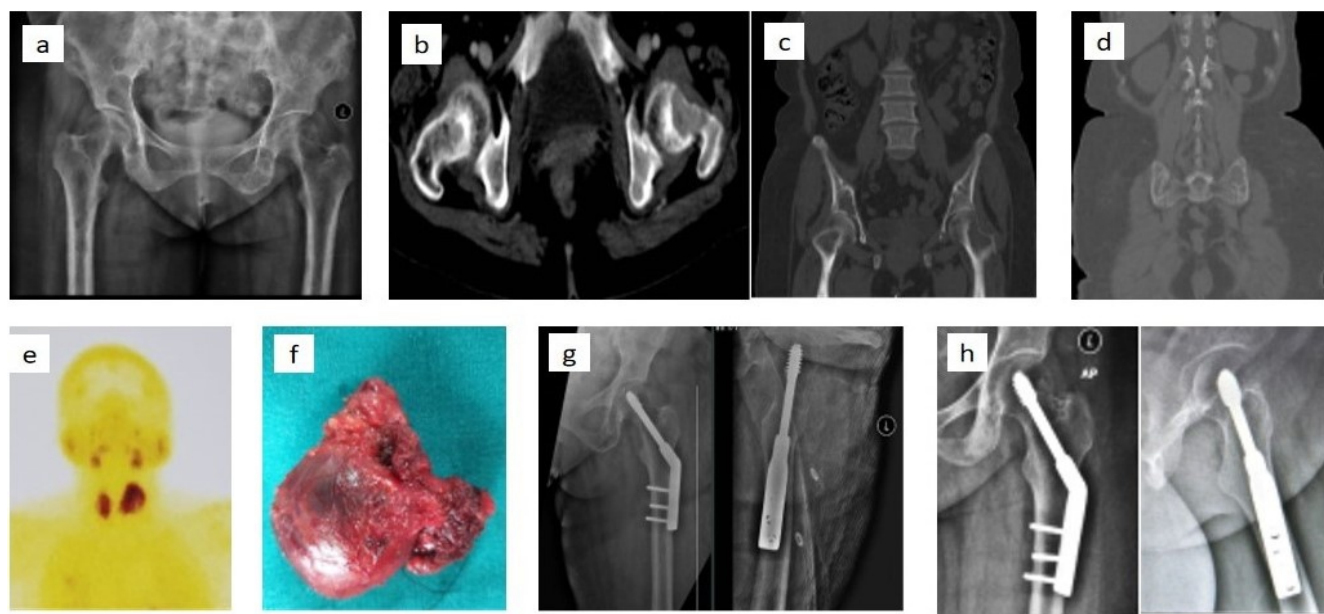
(a) Preoperative X-rays, (b and c) computed tomography scan showing lesions in the left neck of femur, (d) lesion in the sacral ala, (e) Tc99 scan showing enhanced activity in the parathyroid gland, (f) excised thyroid along with parathyroid gland, (g) Dynamic Hip Screw fixation of the left hip in the immediate post-operative period, (h) final follow up showing gradual resolution of the lesion.
